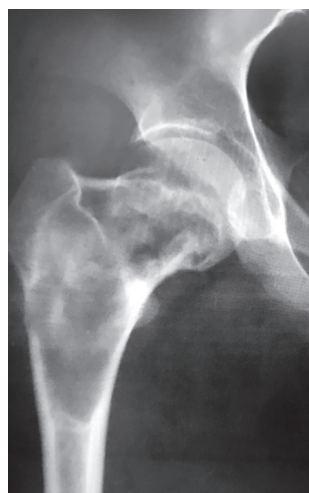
X-ray of the right hip joint before arthroplasty
